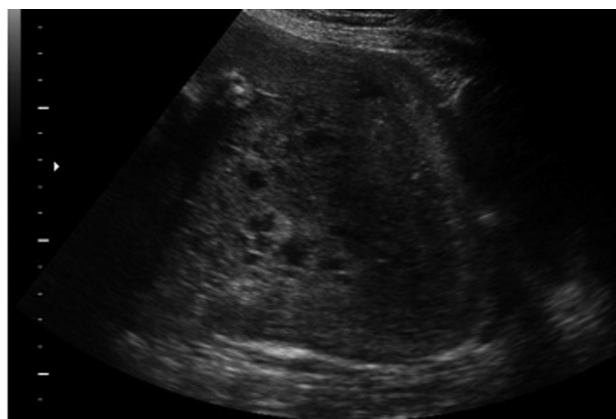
Ultrasound showing molar placenta.
